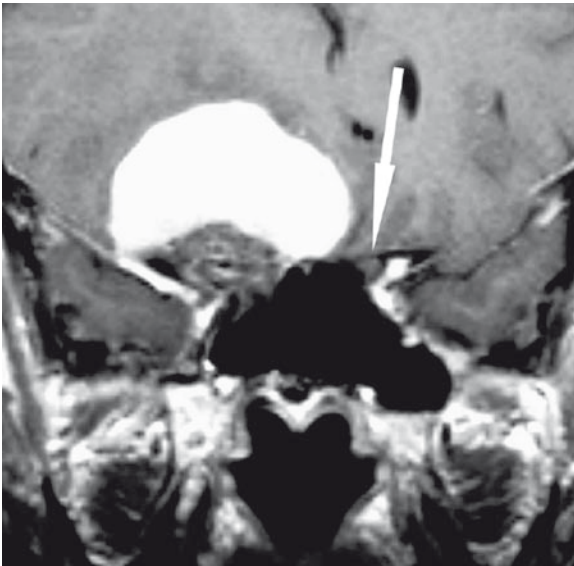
Corresponding axial T1-weighted (T1w), contrast enhanced, fat-suppressed view with signal, enhancement of the tumor (*white arrow*)
